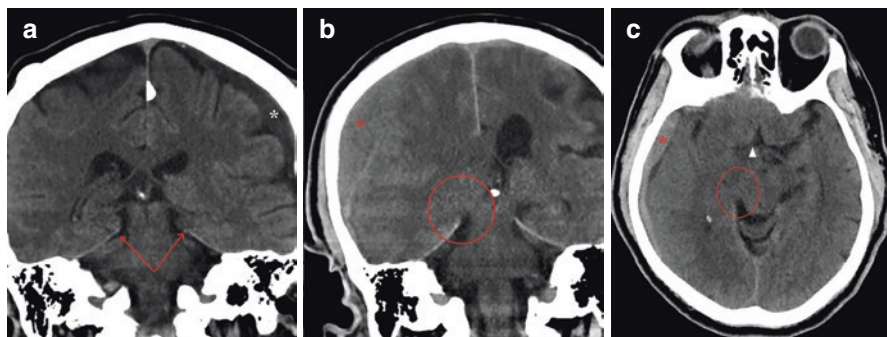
(a) In a normal case, tentorium free edges, ambient systems, and temporal lobe relation (red arrows) are shown. (b) In the case with right subacute subdural hematoma (red asterisk), secondary to the mass effect, the right medial temporal lobe shifts to the midline and obliterates the right ambient cistern. (c) The axial CT image of the same patient shows obliteration of the right ambient (red circle) and suprasellar (white arrowhead) cisterns with the mass effect of the right subdural hematoma (red asterisk)
